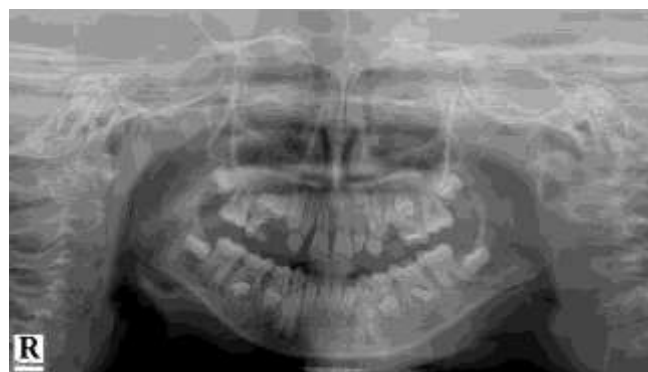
Panoramic radiograph with peg shaped 12 and 22
